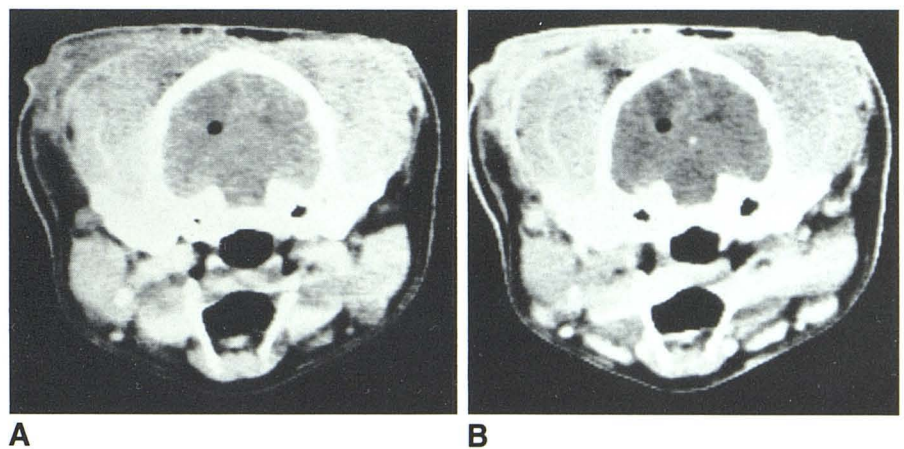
High-resolution GE 8800 CT scans of brain abscess in fig. 1 before (A) and 10 min after (B) bolus intravenous injection of meglumine iohalamate. Minimal, poorly defined enhancement. Intracerebral air, introduced at surgery, is seen on CT and MR (fig. 2).
